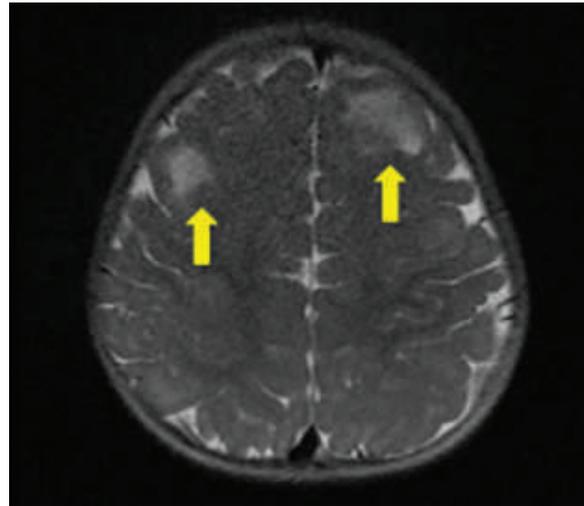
MRI Brain showing T2 hyperintense areas in B/L subcortical region in frontal hemispheres.
